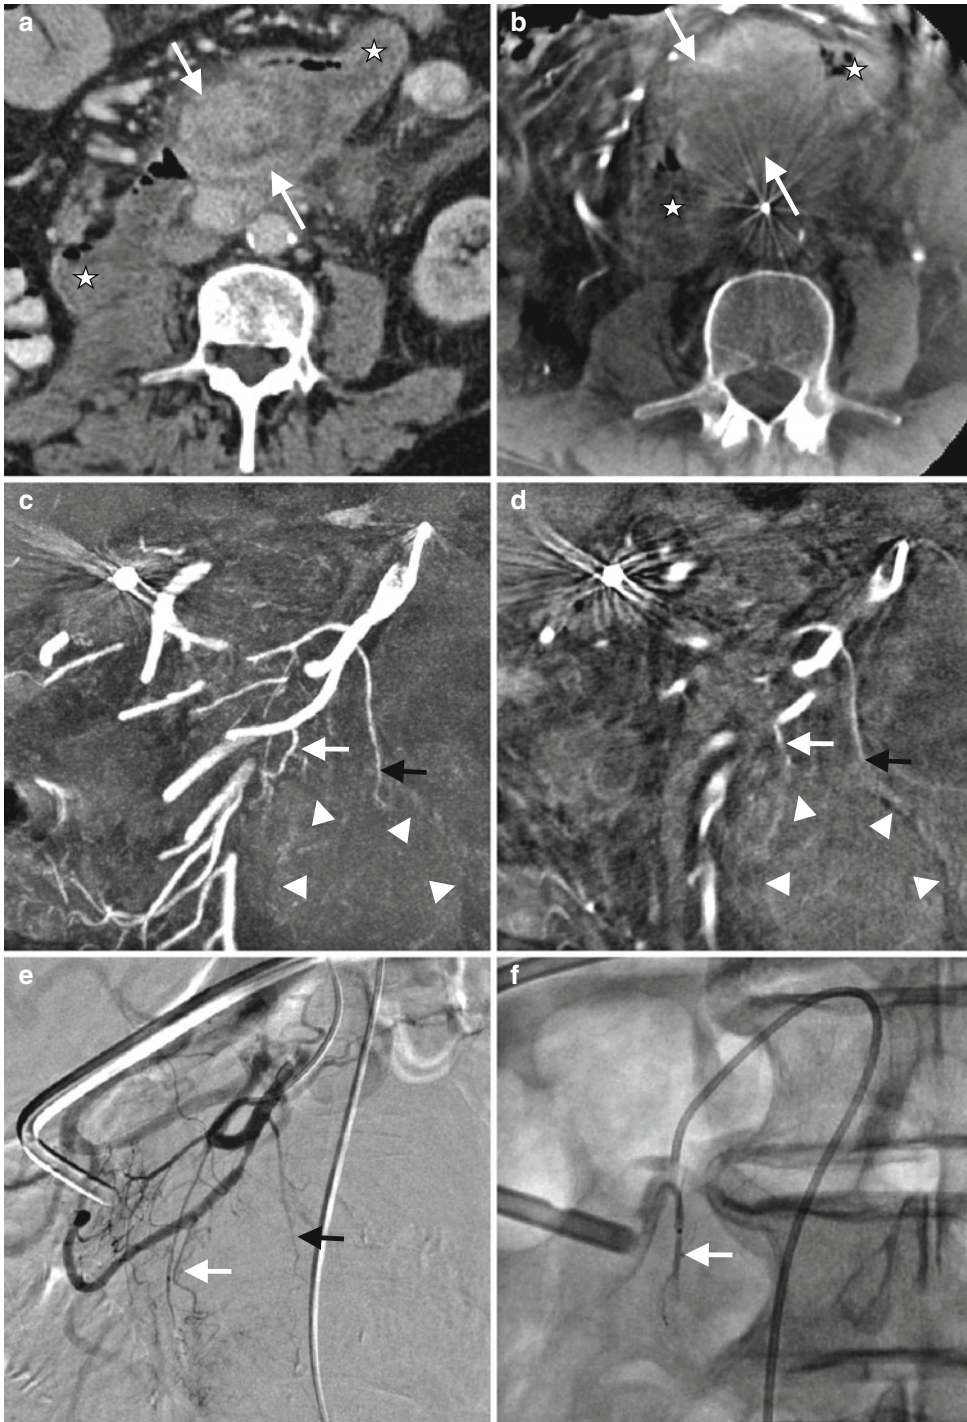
(a–d) Embolization of a liposarcoma infiltrating the duodenum. (a, b) MSCT and C-arm CT of the abdomen show a large tumor (arrows) infiltrating the duodenum (asterisk). (c, d) MIP (15 mm, c) and MPR (5 mm, d) of the C-arm CT in the arterial phase provides information on both feeding vessels as well as soft tissue of the tumor (arrowheads) and the surrounding structures. This enables
